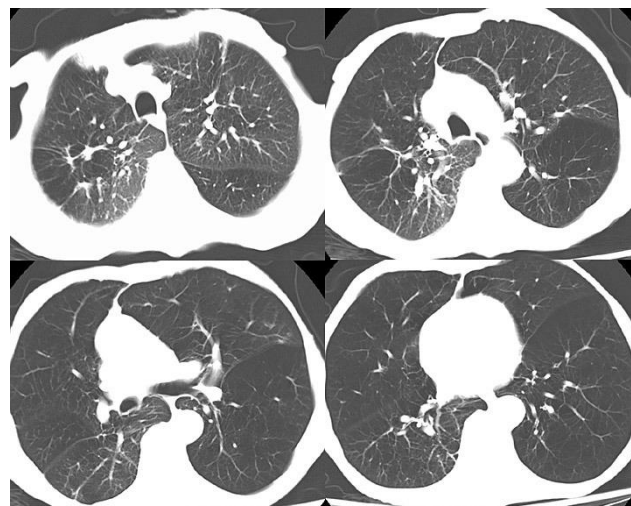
CT scan COPD Left Lung
